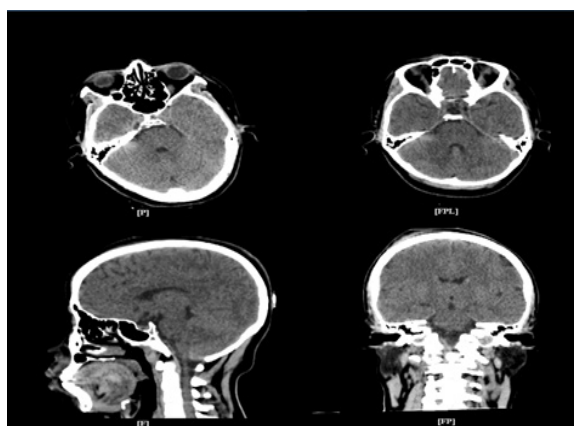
Head CT-Scan showing no signs of intracranial bleeding. Comminuted fracture of the right lateral mass of C1, mild cerebral edema, soft tissue disruption accompanied by soft tissue swelling in the right frontal region, and right pneumo-orbita
